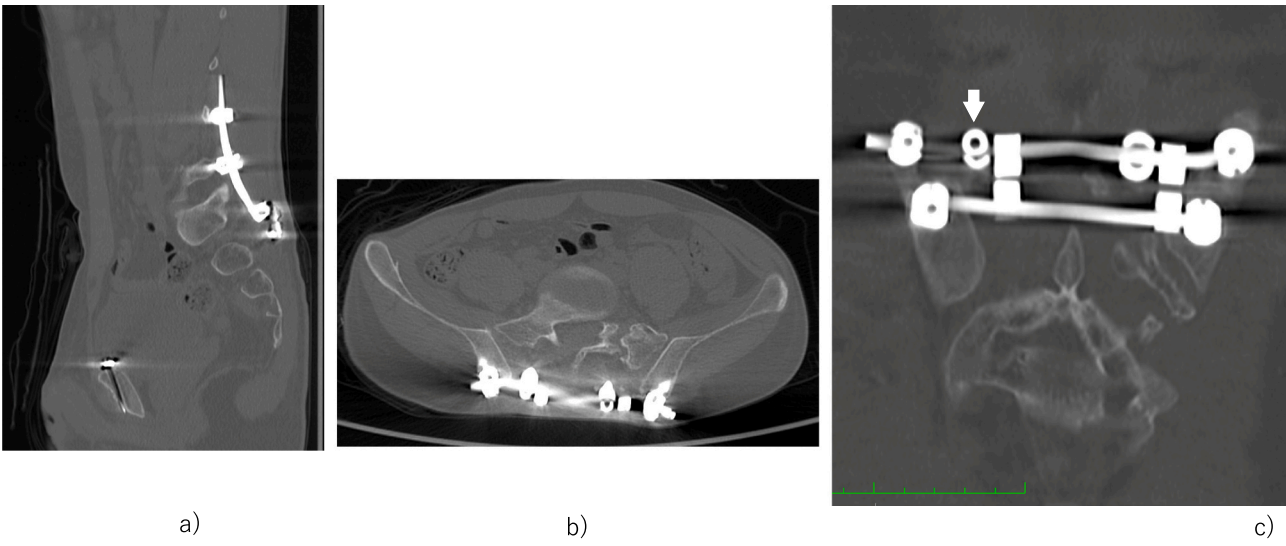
CT sagittal image. (b) CT axial image. (c) CT coronal image. These show loosened 'set-screw' (white arrows) lying outside the screw head.
